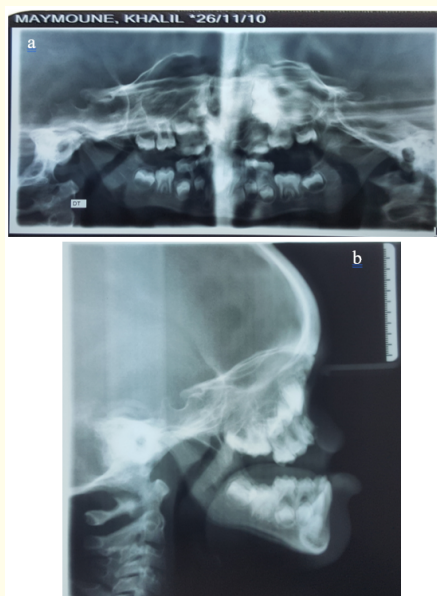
Preoperative x-rays show an absence of the maxillary sinus, the ethmoid bone and the proper bones of the nose. proximity of the germs of the incisors of the internal cortex of the frontal, a condylar symmetry and a crowd tooth in a mixed dentition (a). The lateral cephalometric analysis showed a skeletal Class III, retruded maxilla and hyperdivergent vertical pattern (b).
